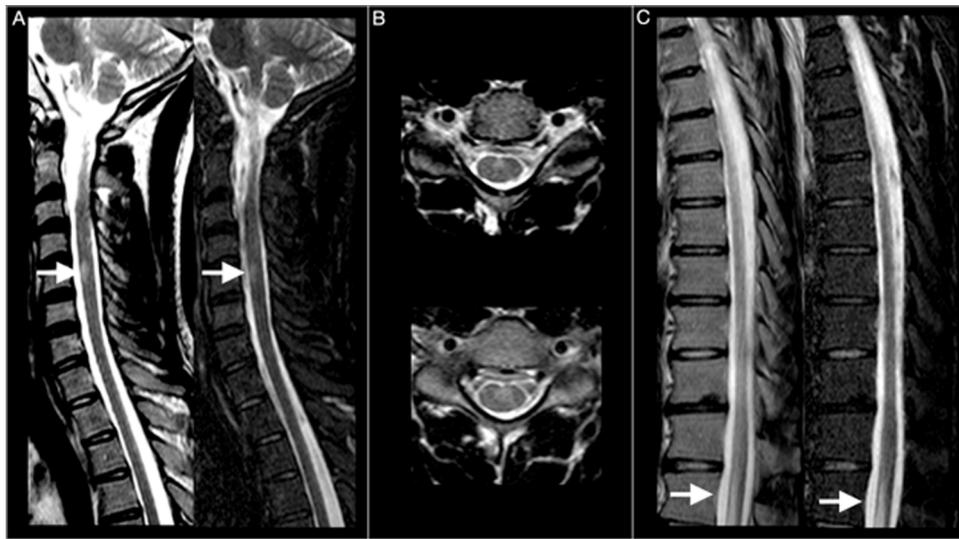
Spinal cord lesions in a MOGAD patient. Brain images from patient number 10. A- Sagittal T2-weighted and STIR, arrows point to an anterior cervical lesion, B-axial T2 weighted showing the pointed lesion in A. C-Sagittal T2-weighted and STIR, arrows point to a lesion in the conus
